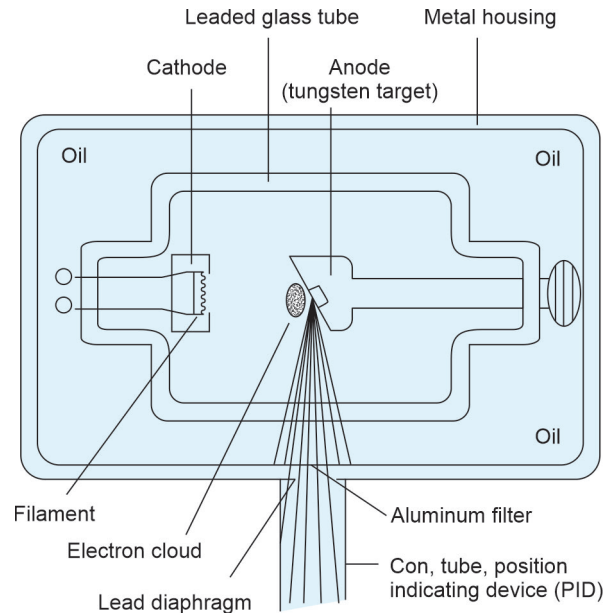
Construction of X-ray tube (Source: Internet)
